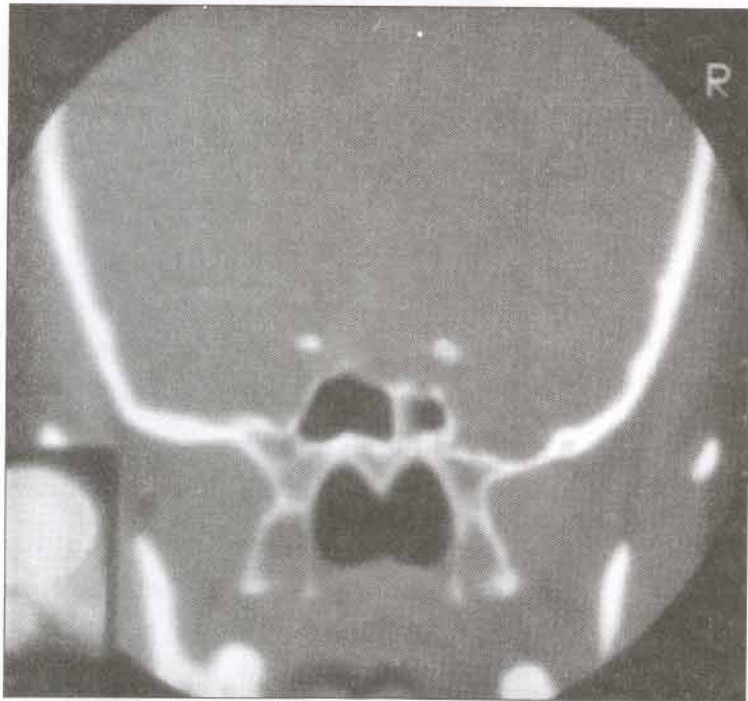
Bone window coronal CT scan picture of the sella turcica showing no evidence of bone erosion.
